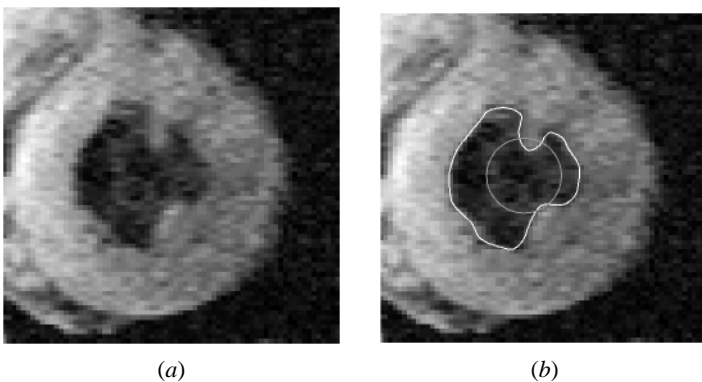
Extraction of the inner wall of the left ventricle from a magnetic resonance image using active contours. (a) Original image. (b) Initial active contour and the final converged result.
